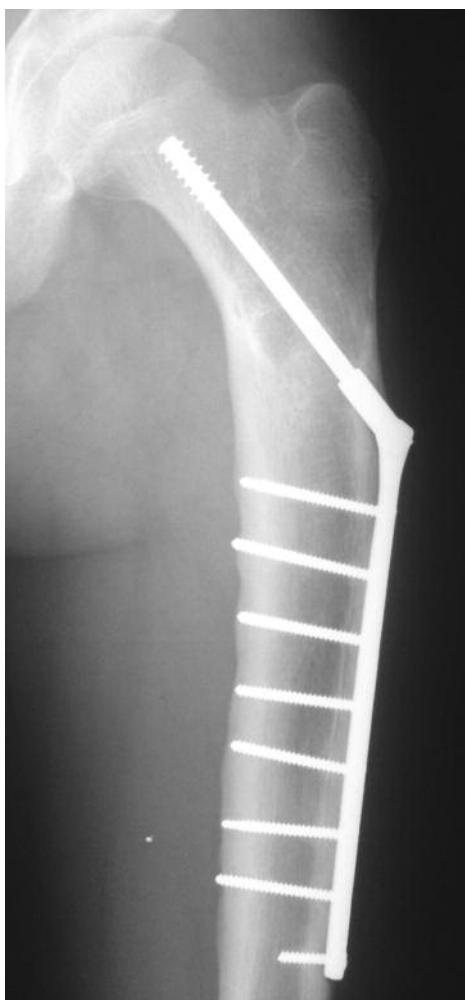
Radiograph of the same patient 12 months after surgery. The cavity is filled with new bone.
